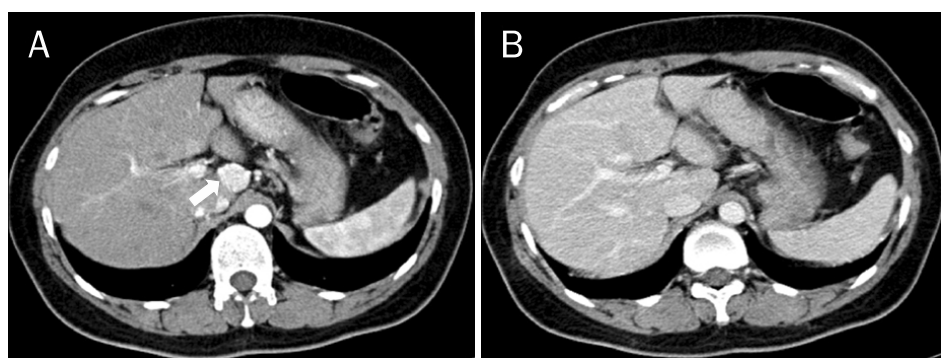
Liver CT findings. (A) CT image on hepatic arterial phase showed a 2.1 cm diameter enhancing mass in the caudate lobe of the liver (arrow). (B) CT image on delayed phase showed that the nodule became isodense, compared with the liver parenchyma.
